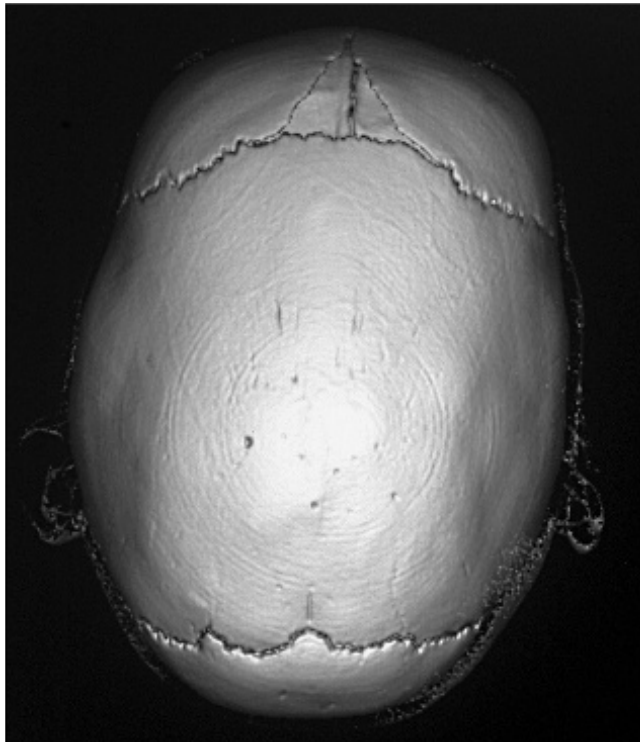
3D CT scan of patient with scaphocephaly. Note the absence of sagittal suture.
